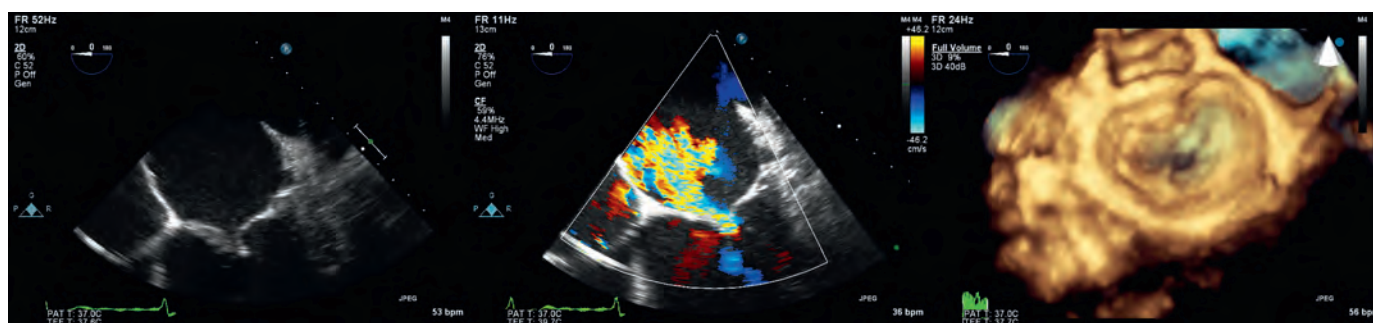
Mitral regurgitation Type IIIa. (Left and center) Midesophageal four-chamber view reveals the thickened mitral valve leaflets that are seen coapting below the level of the annular plane. Although not apparent on the still images, leaflet movement both during systole and diastole is restricted, which is characteristic of type IIIa mechanism. In this particular case, the posterior leaflet is thicker with a more restricted movement. (Center) Color-flow Doppler demonstrates a large jet directed toward the restricted posterior leaflet. (Right) The three-dimensional reconstruction reveals the restriction of the mitral valve leaflets. (Video available online.)
